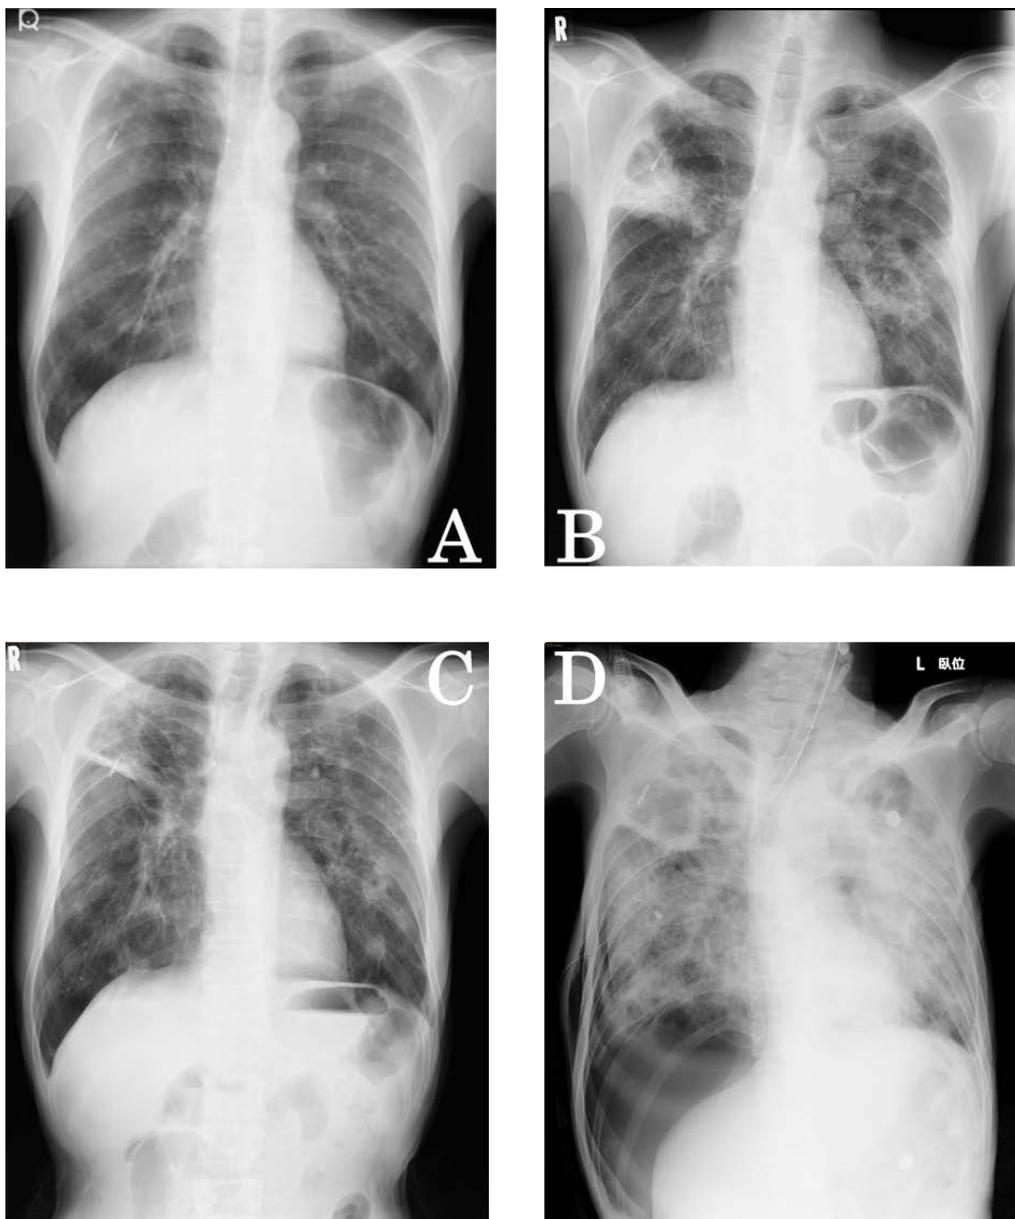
Chest radiograph demonstrating bilateral small consolidations 6 months ago (A), a large cavitary lesion surrounded by ground-glass opacities in the right upper lobe on admission (B). Cavitary lesions were not getting worse after 3months of discharge (C). He died of respiratory insufficiency after disclosing a pneumothorax due to lung metastases 6 months after discharge (D).
